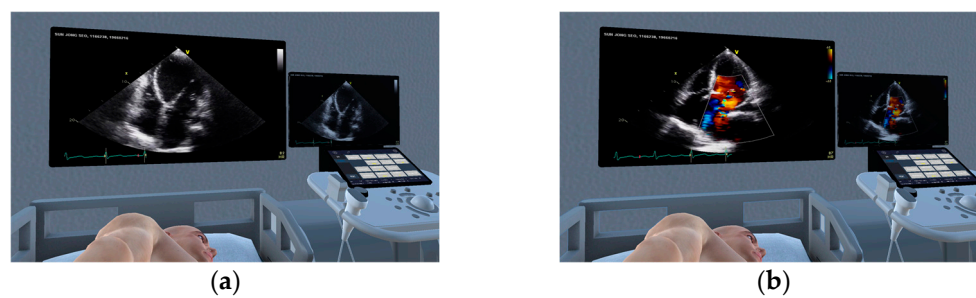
Changing the mode of the echocardiography examination view: (a) B-mode and (b) M-color mode.
